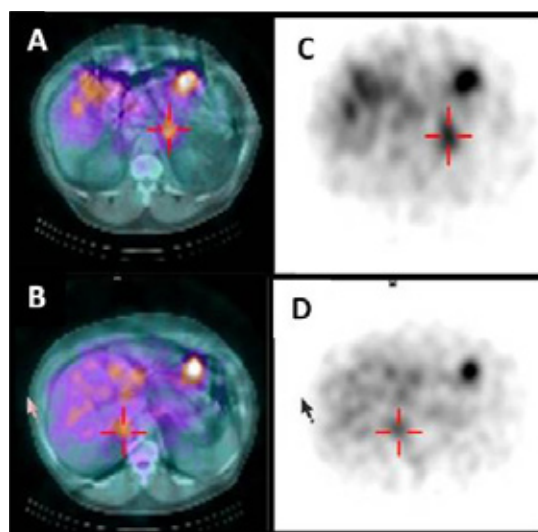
The SPET/CT study of the same patient (Fig. 4) at day 3. A and B are the fused SPET and CT images of the left and right adrenal and C and D the respective SPET images. There is clear visualization of both adrenals confirming IHA (BAH). (Images from the department of Nuclear Medicine University Hospital Rion-Greece)
